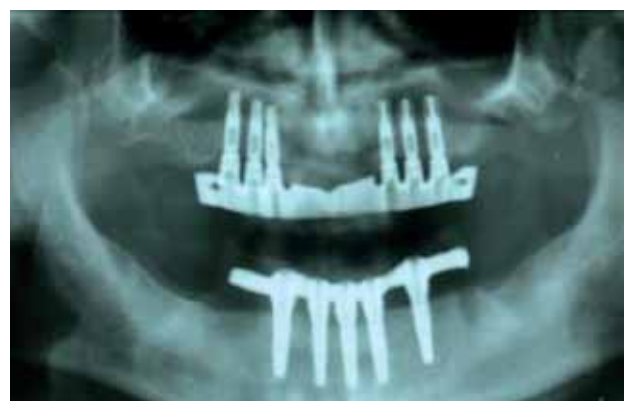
The panoramic radiographs taken immediately after surgery and 18 months postoperatively.
